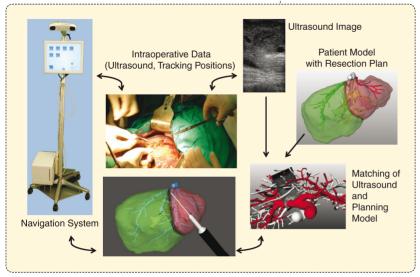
Integration of components for navigated surgery. The navigation system (CAScination AG and University of Bern, Switzerland) tracks the position of instruments and the ultrasound transducer in the operating room. The virtual liver model including the resection plan is matched to the ultrasound images based on landmarks and vascular structures. The combination allows for real-time visualization of instruments in the liver model and more accurate implementation of the treatment plan.
